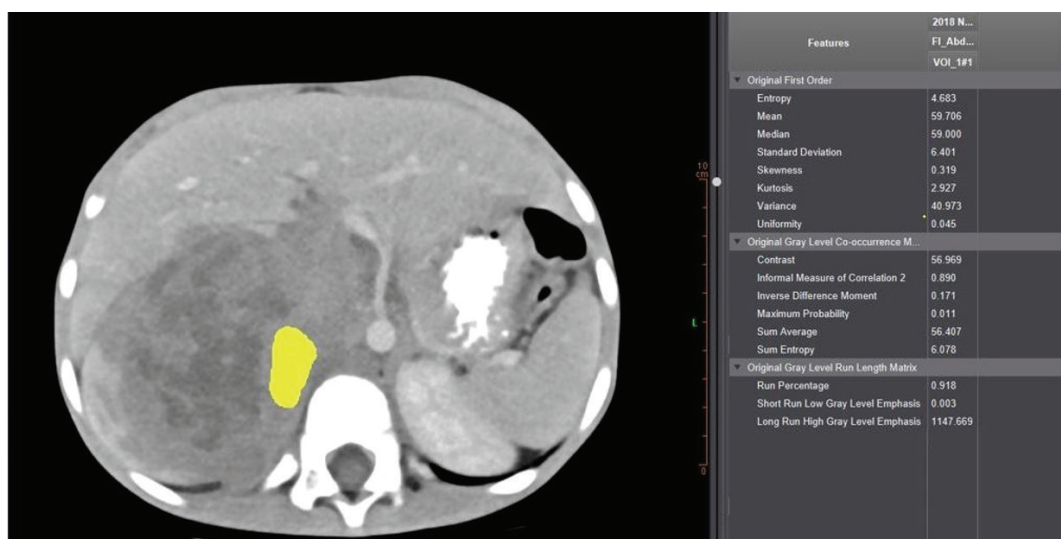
Axial contrast-enhanced CT images: in the case of NB, the tissue analysis program monitors the results of the tissue analysis of the ROI area (yellow area) and statistical parameters drawn on the solid mass in the right adrenal area
